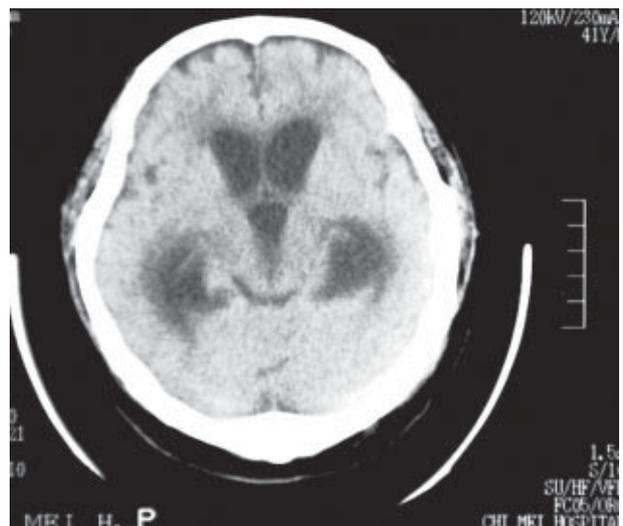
Follow-up brain computed tomography reveals prominent temporal horns and enlargement of ventricles.
